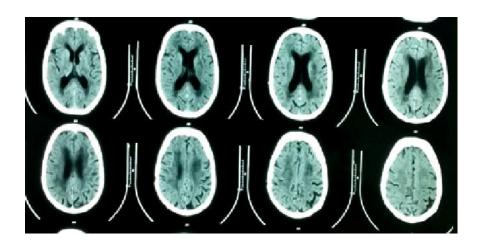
CT brain one month post operative shows complete resolving of the CSDH
